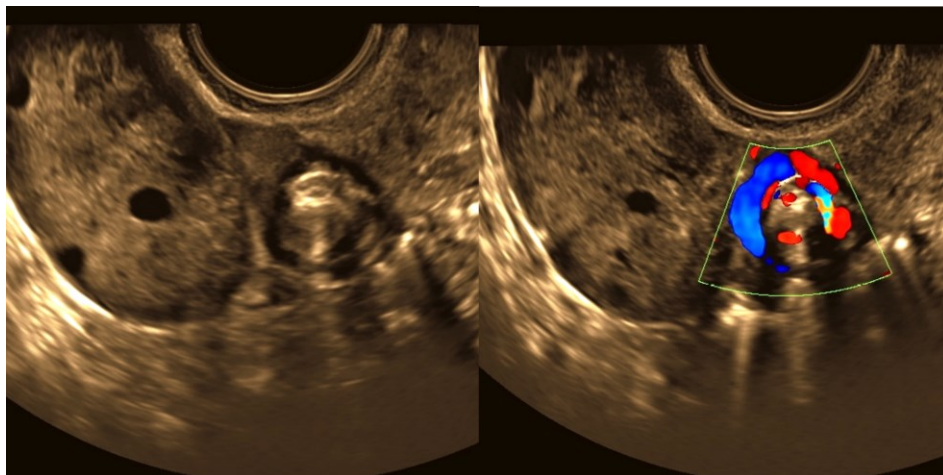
The “whirlpool sign” on color Doppler and grayscale.
